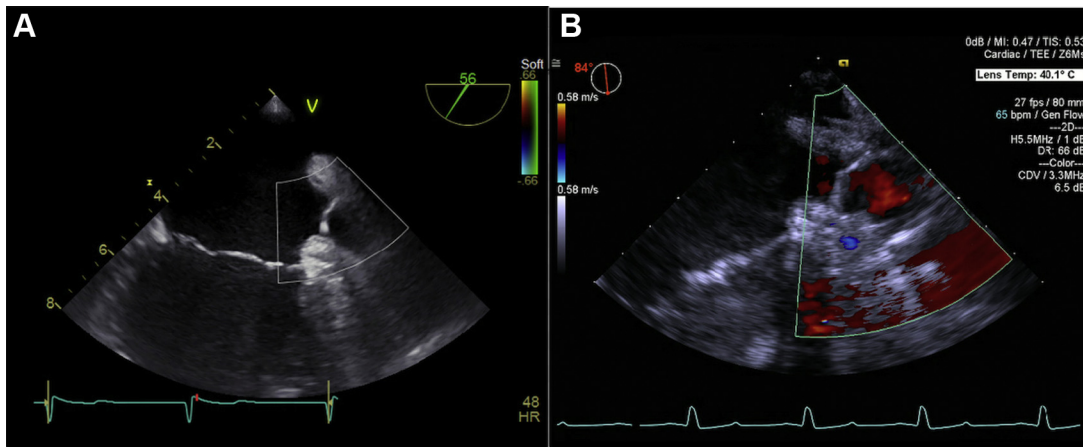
Transesophageal Echocardiogram Directly After Implantation
